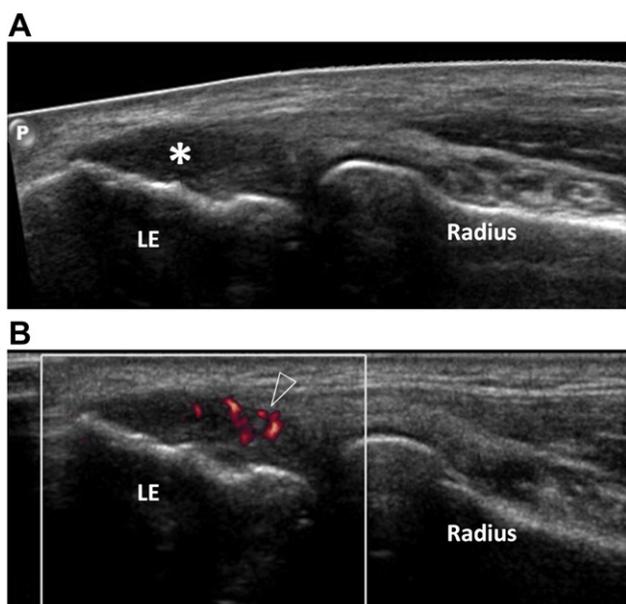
Sonographic pictures of common extensor tendon at lateral elbow. (A) Hypoechoic change of the tendon (*) at its insertion to the lateral epicondyle (LE). (B) Intratendinous hypervascularity (open arrowhead).
